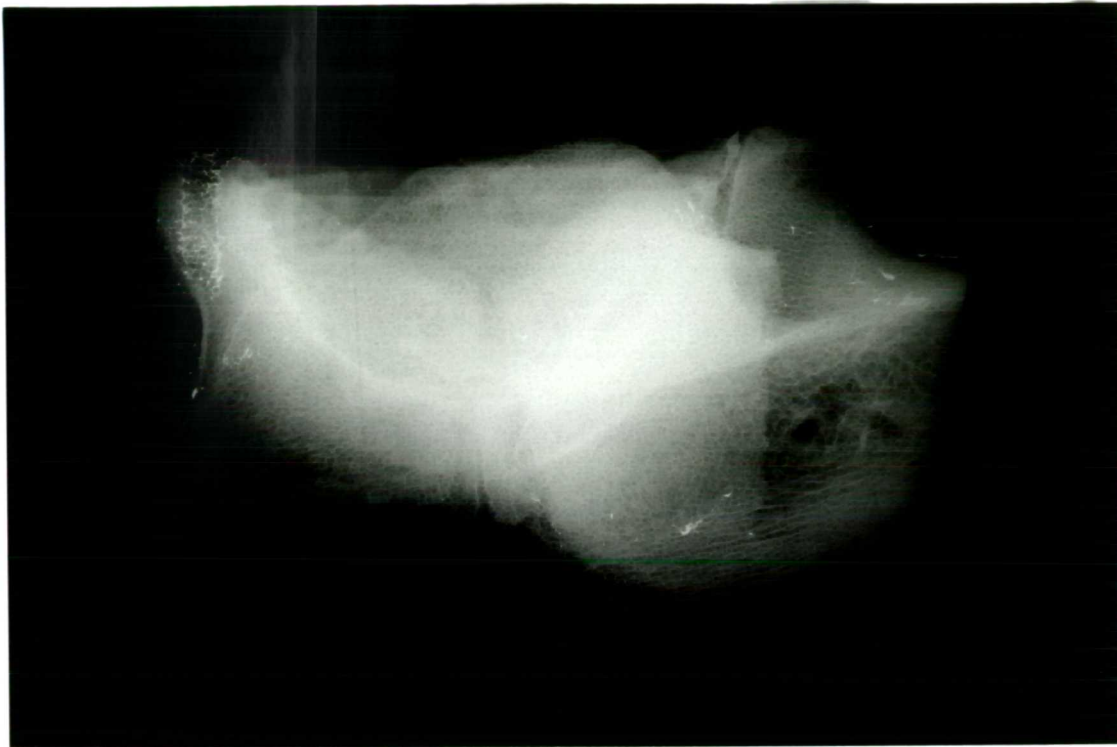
Radiographic appearance cement bone interfaces. Qualitatively the worst (case 1, left) and best (case 2, right) are shown.
